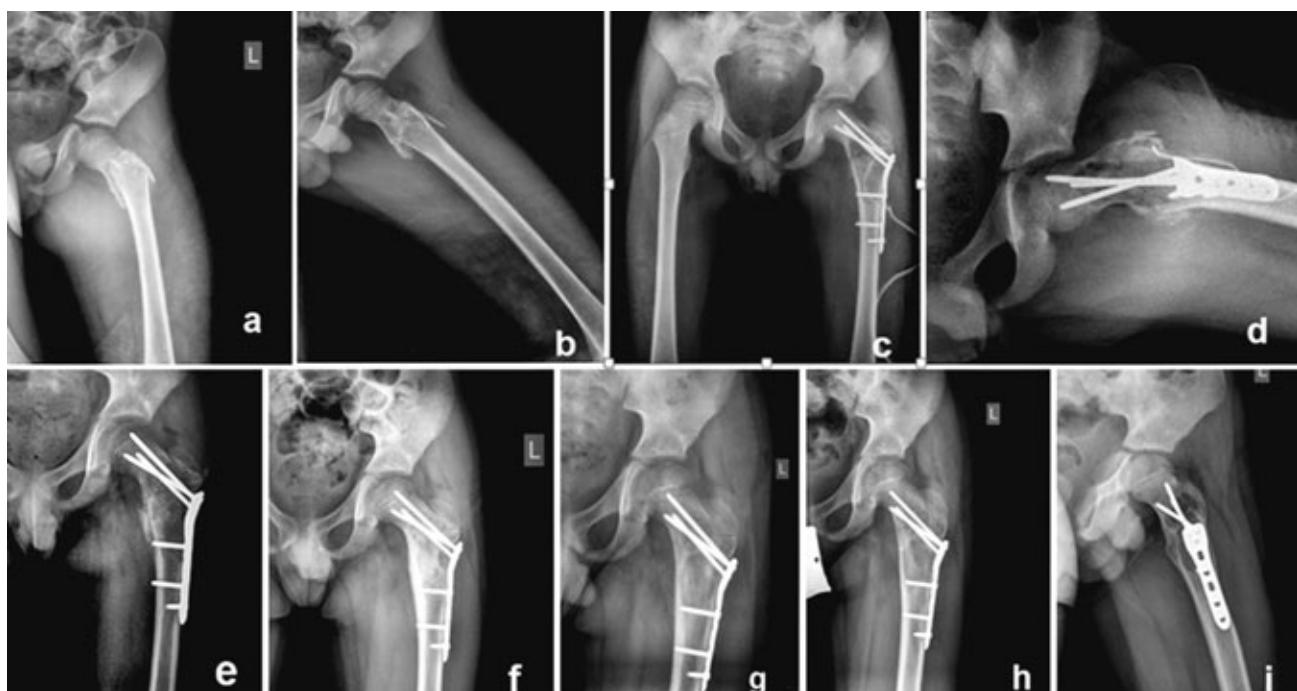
Case № 1. a,b,c,d – diagnostic and intraoperative X-rays, e,f,g – X-ray on the 3th, 6th (bone healing) and 18th month after the operation, h,i – final follow-up X-ray, Capanna grade II.
